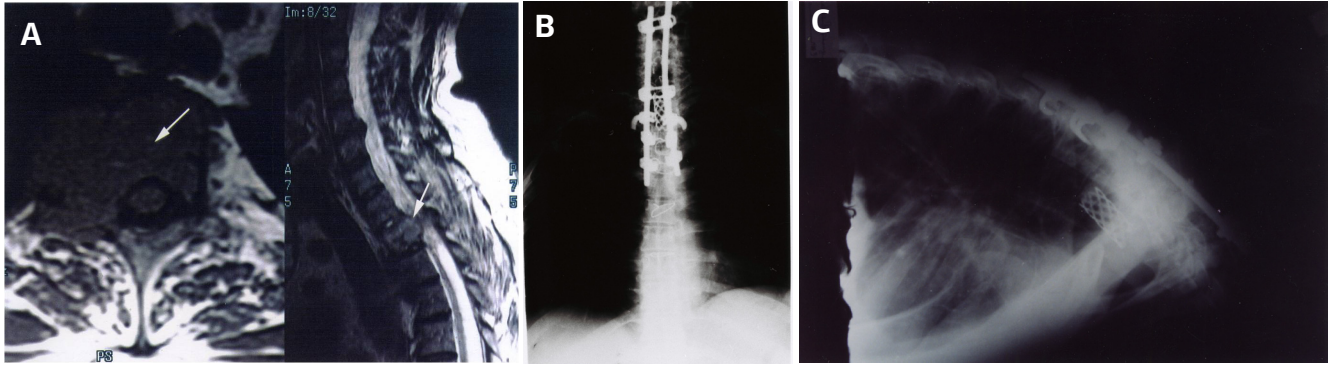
Sagittal and axial T1-weighted MRI with gadolinium demonstrating an isointense tumor involving T2 vertebral body (A). Postoperative anteroposterior and lateral radiography demonstrating methylmethacrylate – cage construct and plate fixation (B, C).
